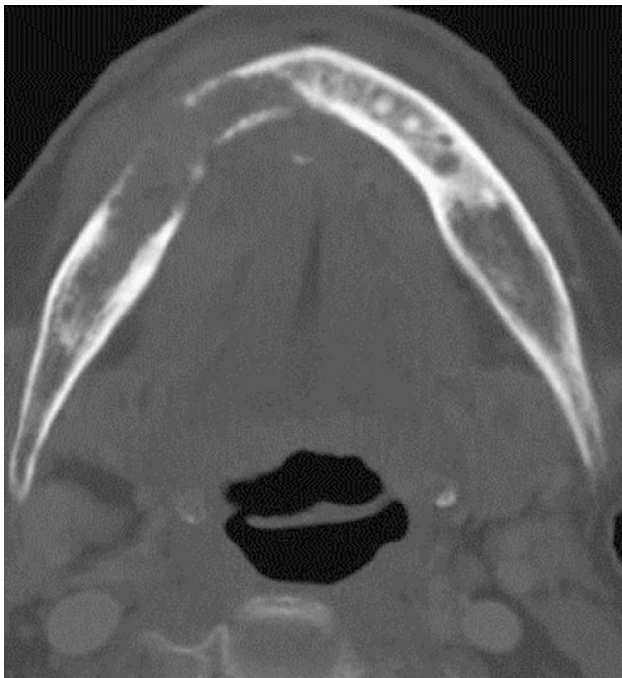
Axial section of CT scan (bone window) revealing oral carcinoma eroding adjacent mandible on right side.
